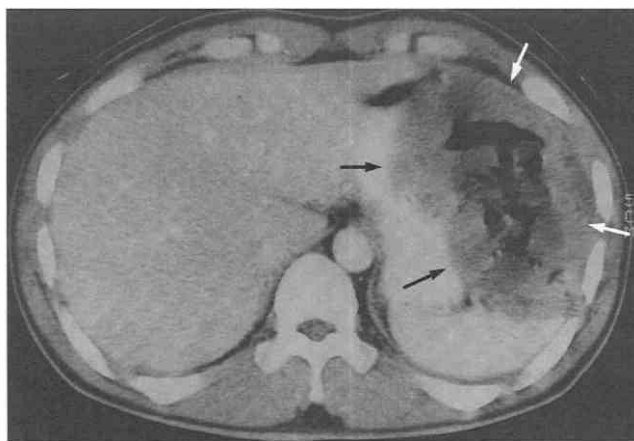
Infected malignant gastrointestinal stromal tumor of the stomach. CT scan shows a large, heterogeneous mass (arrows) with central cavitation and gas collection. The small orifice of the ulcer in the tumor was considered to be the cause of secondary infection.
